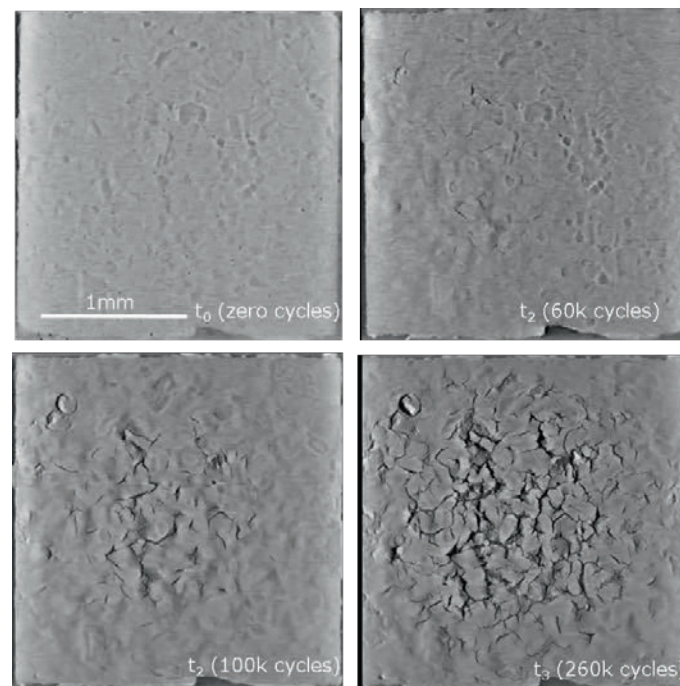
Virtual X-ray tomography cross-sectional images of a sintered Ag joint die attachment showing evolving microstructures under power cycling
